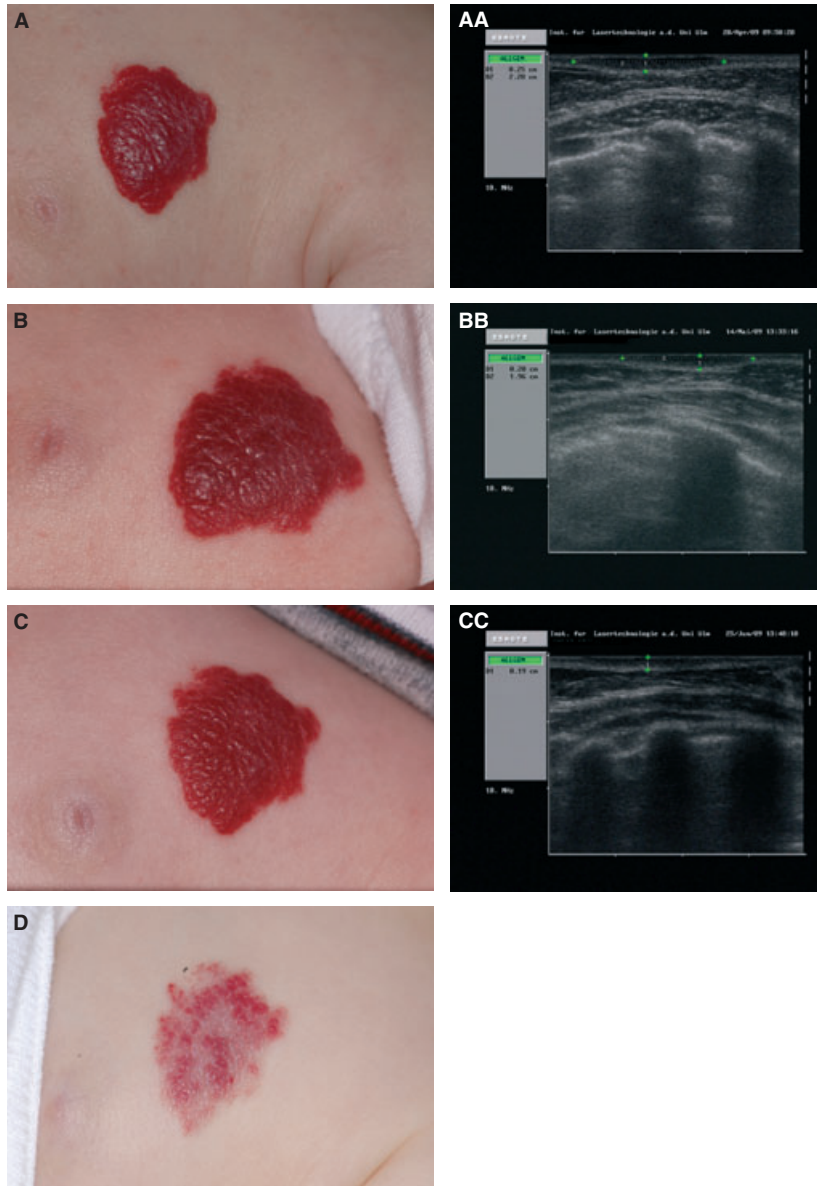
Superficial hemangioma on the breast of a girl (Patient 1 in Table 1) (A) at the age of 10 weeks, before starting topical propranolol therapy. (AA) Matched ultrasound picture, maximum thickness of the hemangioma 2.5 mm. (B) After 17 days topical propranolol treatment. (BB) Ultrasound measurement showed flattening of the lesion, maximum thickness 2.0 mm. (C) Minimal change after 8 weeks of therapy. (CC) Maximum thickness 1.9 mm. (D) After 6 months of topical propranolol therapy.
